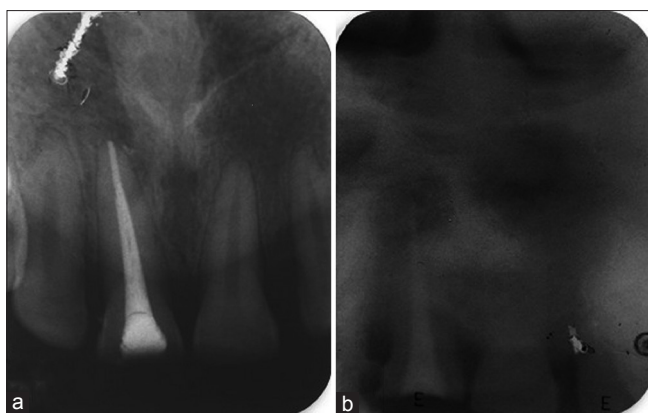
(a) Intraoral periapical postobturation radiograph of the maxillary central incisor. (b) Extraoral periapical postobturation radiograph of the maxillary central incisor
